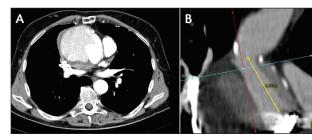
CT angiogram showing a pseudoaneurysm of the ascending aorta after a previous Bentall surgery (A, axial; B, coronal exams), which was treated at our institution.
